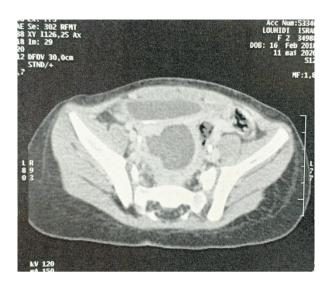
CT image in cross section showing an intervesico-rectal tumor process of tissue density with contrast enhancement
